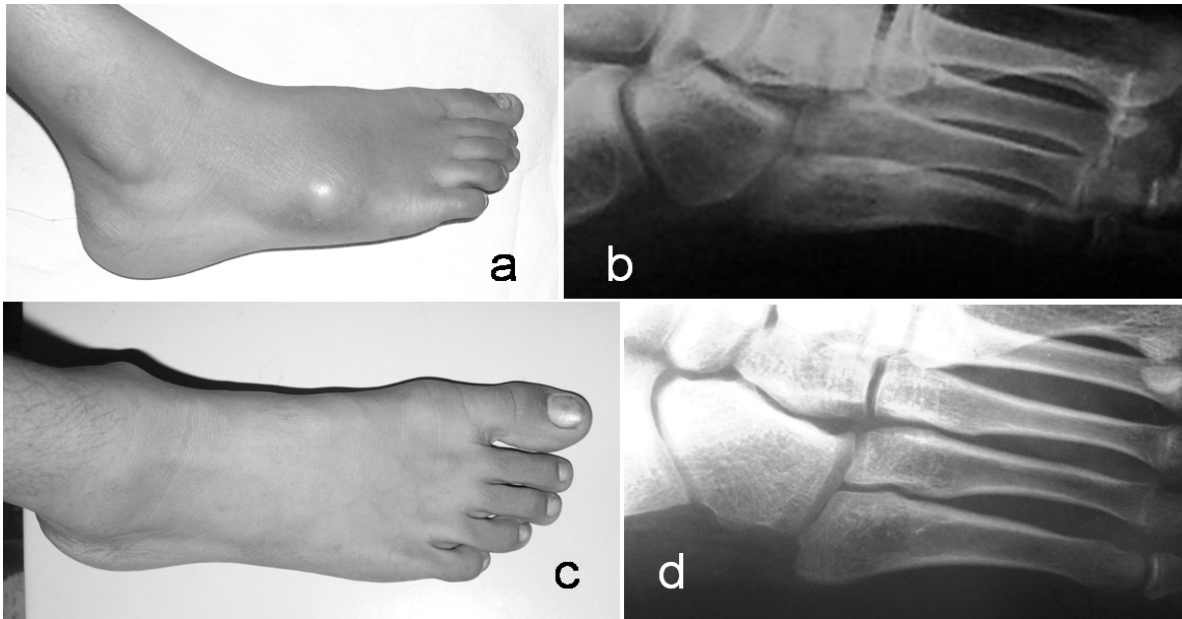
Case 5. a) Acute suppurative presentation of osteoarticular tuberculosis of 5th metatarsal. b) Plain radiographs showing lytic areas and expansion of base of 5th metatarsal. c) Resolution of abscess following antitubercular treatment in six weeks. d) The lesion in the bone resolved in five months.
